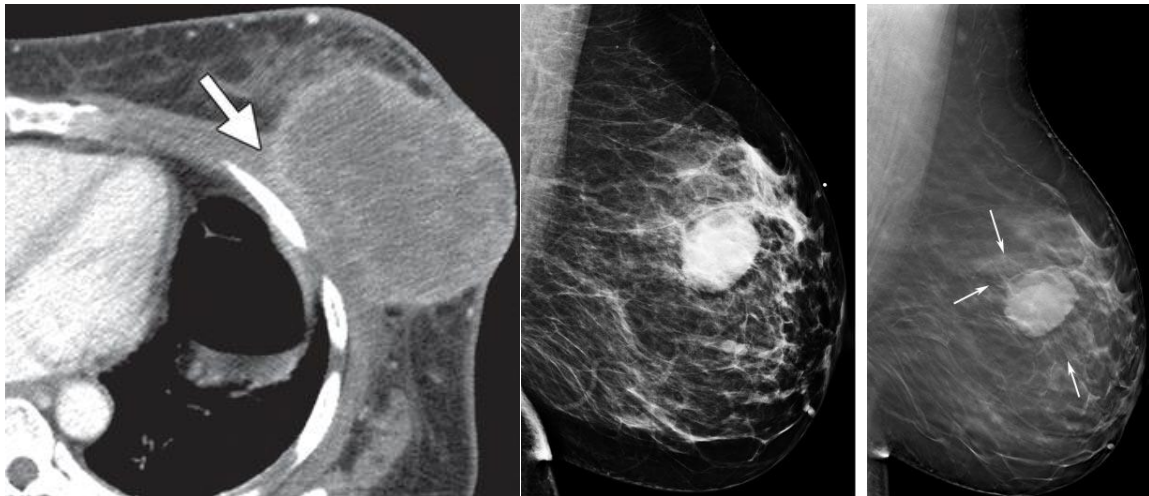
3 This image is Invasive ductal carcinomas. (a) A rim-enhancing irregular mass is visible on contrast-enhanced CT images. (b) The dense lump (arrow) is ill-defined anteriorly on craniocaudal mammography of the right breast. (c) The dense lump (arrow) is ill-defined anteriorly on ultrasound imaging.[4]
